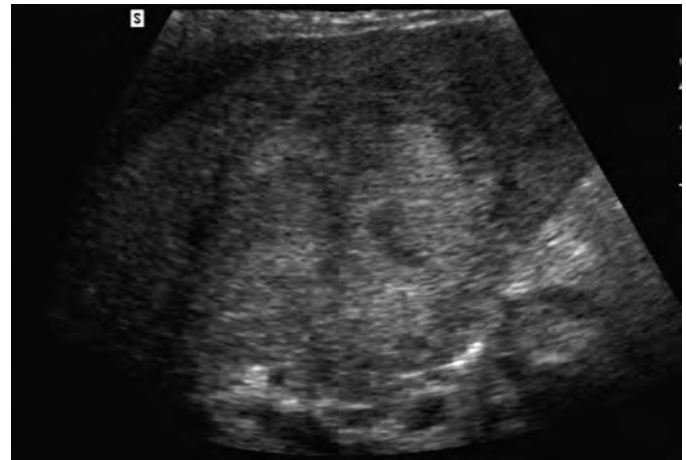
FLC: ultrasound findings. The extensive fibrosis present within this neoplasm accounts for the echogenic appearance of this mass.
